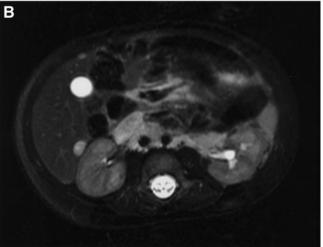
Abdominal MRI in 3-mo-old child with unresectable retroperitoneal neuroblastoma (A) and hepatic lesions (B). Extent of disease was poorly defined using CT. All masses and bone marrow disease spontaneously regressed.
